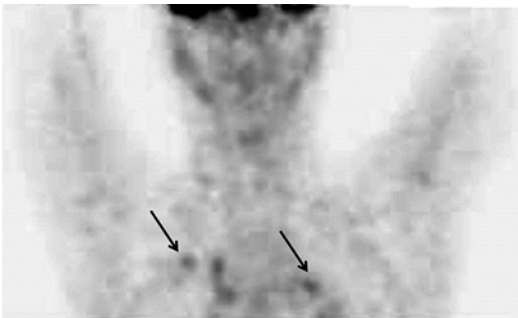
Interim PET/CT scan did not present any uptake in the originally detected lymphoma sites. Lung lesions identified (*arrows*) were considered infectious (SUVmax of 1.7)
